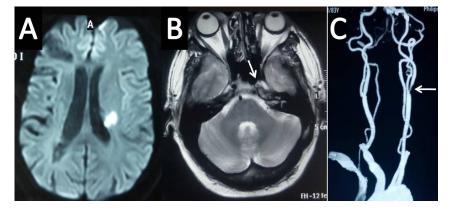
Heterogeneous hyperintense intraluminal signal. Diffusion Weighted- MRI (A) shows acute infarct in Left Periventricular region. T2 Weighted-MRI (B) shows Heterogeneous Hyperintense (hyperintense rim with Isointense centre) intraluminal signal in left ICA (arrow). CT Angiography of neck vessels (C) shows severe stenosis at origin of the cervical portion of left ICA (arrow).
